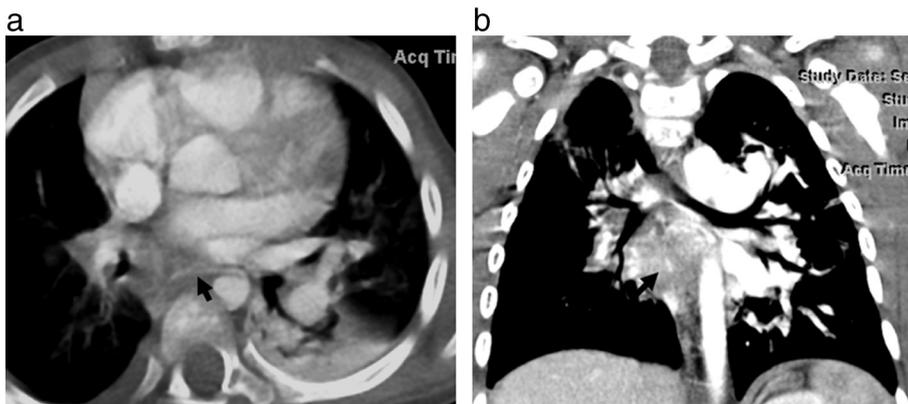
(a,b): Axial (a) and Coronal (b) contrast-enhanced CT images of the chest at age 4 years demonstrate soft tissue density in the right middle mediastinum and right hilum. The right-sided bronchi are patent. Note the enhancing vessels coursing through the mediastinal soft tissue process (arrows). On the axial image this represents a large bronchial artery.
